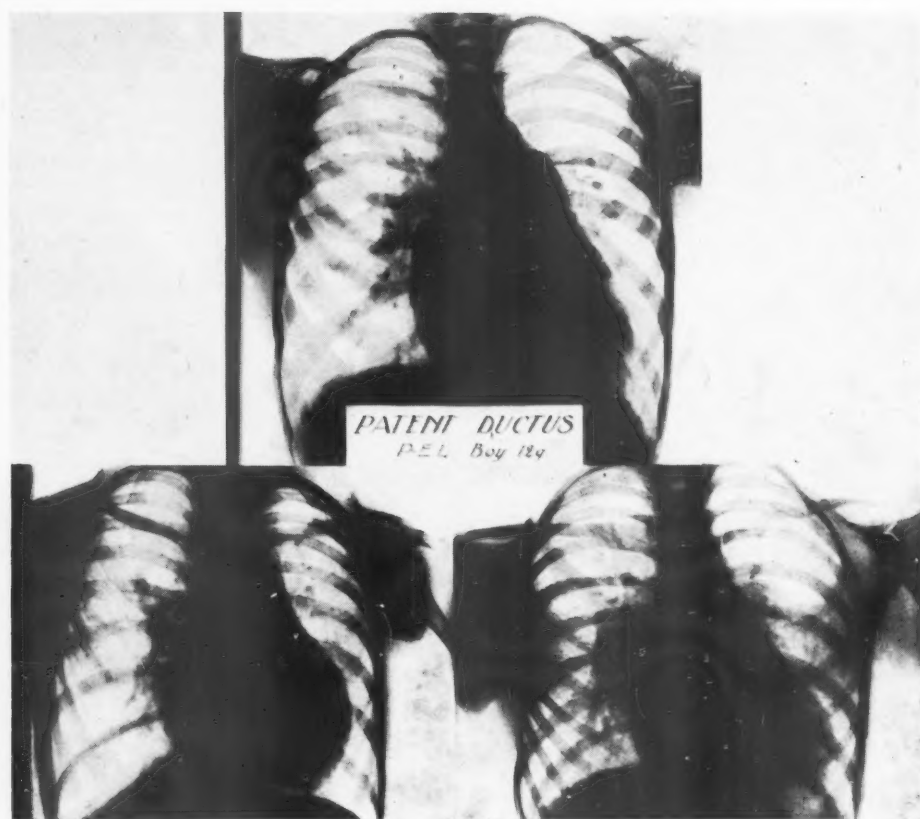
Radiographs of one case of patent ductus arteriosus and two of interventricular septal defects; all three showed evidence of increased pulmonary blood flow.
